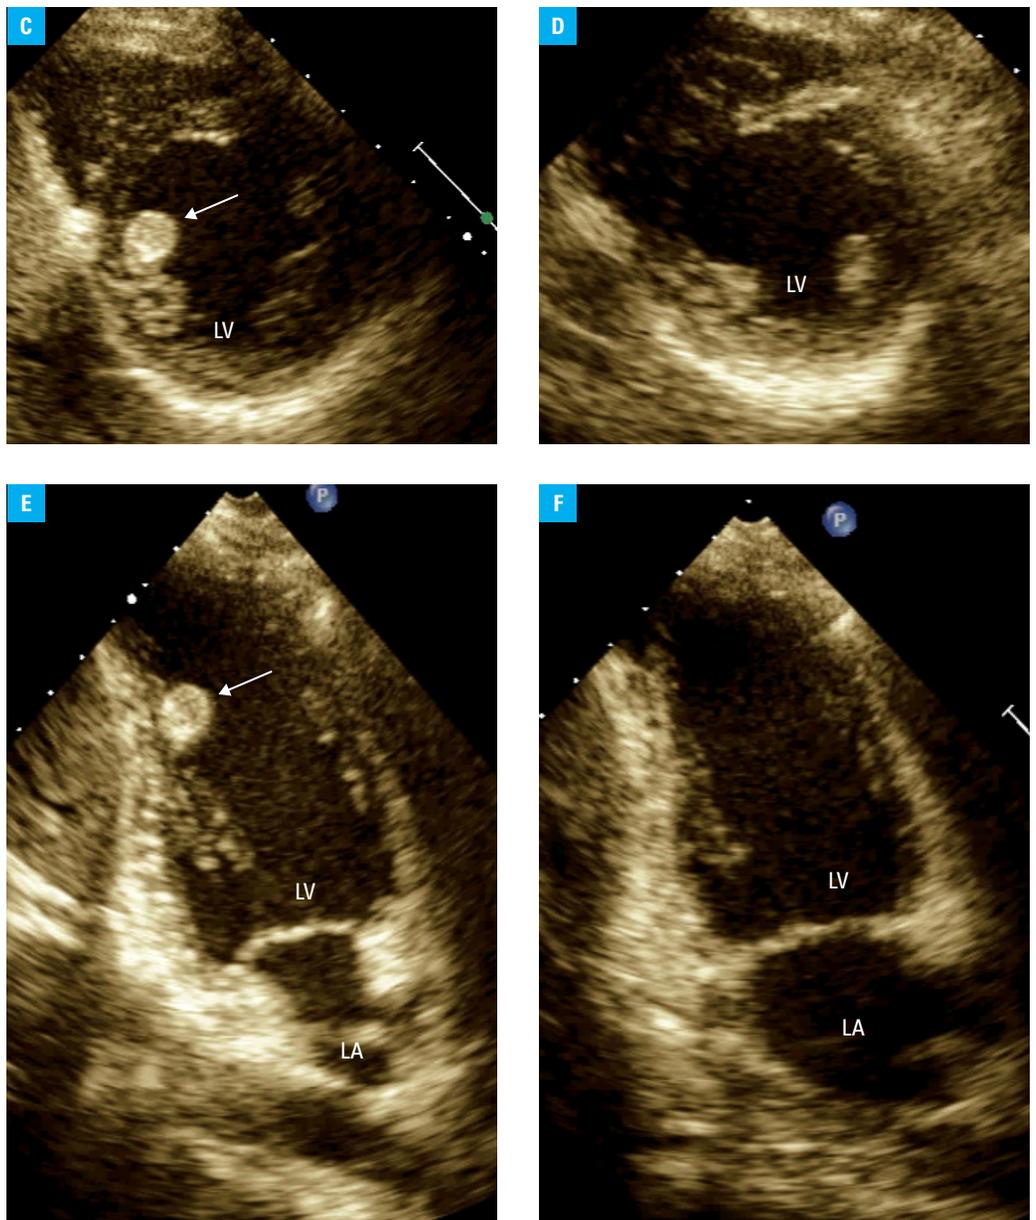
Transthoracic echocardiography in a patient with left ventricular (LV) rhabdomyoma before and at 1 year after the surgery: A – an additional spherical mass in the left ventricle (arrow), subcostal view; B – 3-dimensional image of the pathological structure (arrow)
